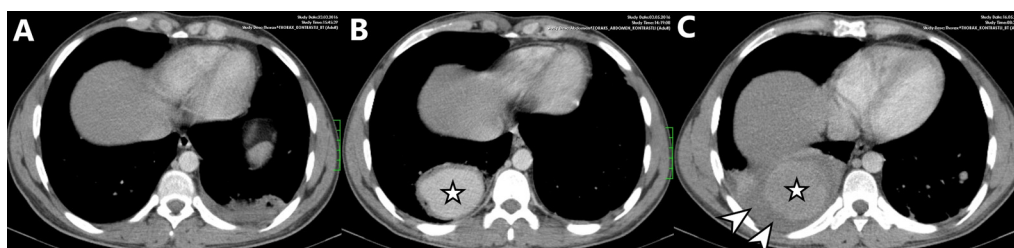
In a 25-year-old male patient diagnosed with Hughes Stovin syndrome, a newly formed aneurysm in the lower lobe of the right lung, which was not previously seen on contrast-enhanced thorax CT (A), is seen on CT taken 1.5 months later (star, B). In the CT taken 2 weeks later due to complaints of hemoptysis, rupture of the aneurysm and fluid densities (arrowheads) extending to the pleural space around the aneurysm are observed (C).
